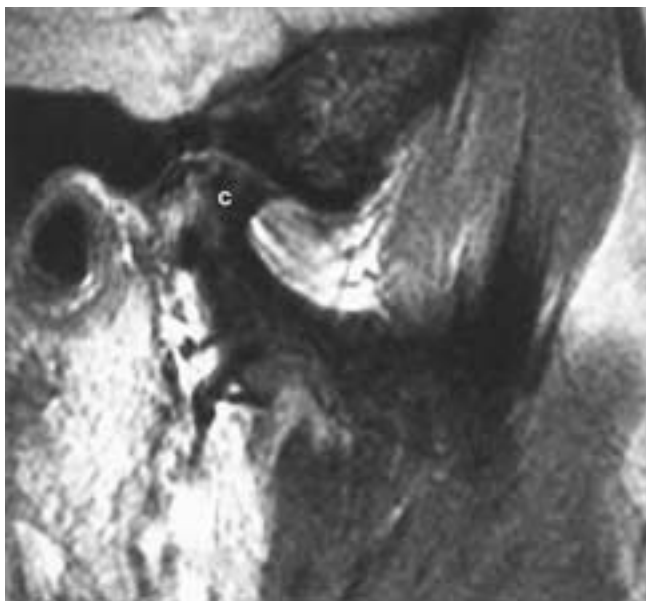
Sagittal proton density MR image showing degenerative changes of the mandibular condyle (C). A core biopsy of this condyle showed avascular necrosis.
